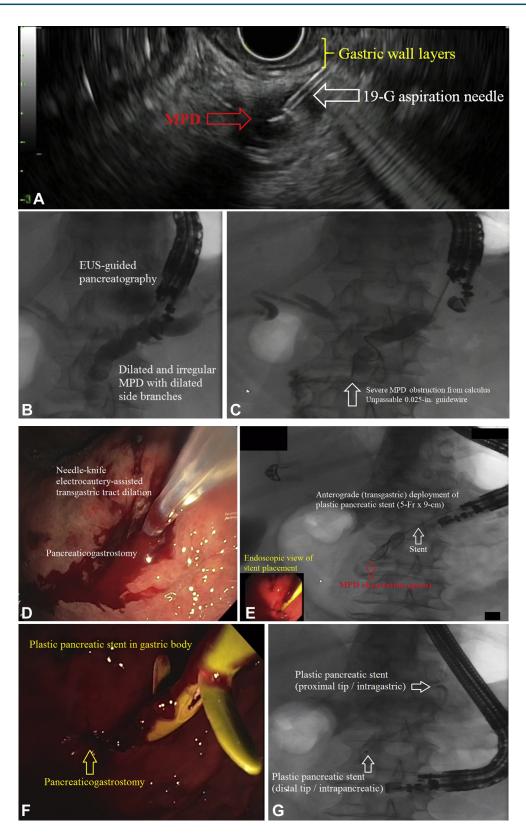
A, Endosonographic view of EUS-guided transgastric MPD access. A 19-gauge aspiration needle is accessing the dilated main pancreatic duct (MPD; 10.5 mm) in the body of the pancreas. B, Fluoroscopic view of EUS-guided transgastric pancreatography. A filling defect is present in the genu of the pancreas. The proximal MPD is irregular and dilated to 10.5 mm in the body of the pancreas. Multiple irregular side branches are present. C, Fluoroscopic view of attempted transgastric (anterograde) guidewire passage. The 0.635-mm (0.025-inch) guidewire is unable to traverse a high-grade MPD obstruction located in the genu. Rendezvous-assisted endoscopic retrograde pancreatography is no longer an option. D, Endoscopic view of needle-knife cautery-assisted transmural tract dilation in preparation for anterograde guidewire-assisted pancreatic stent passage. (*legend continued on next page*)
